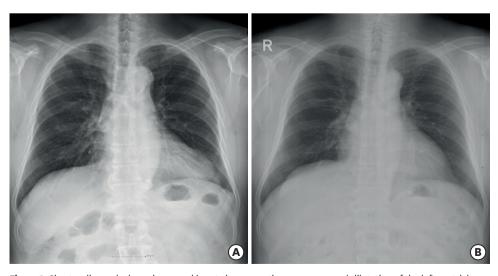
Chest radiograph shows increased heart size suggesting an aneurysmal dilatation of the left ventricle (A), which was not seen in the chest radiograph taken 12 years ago (B).
